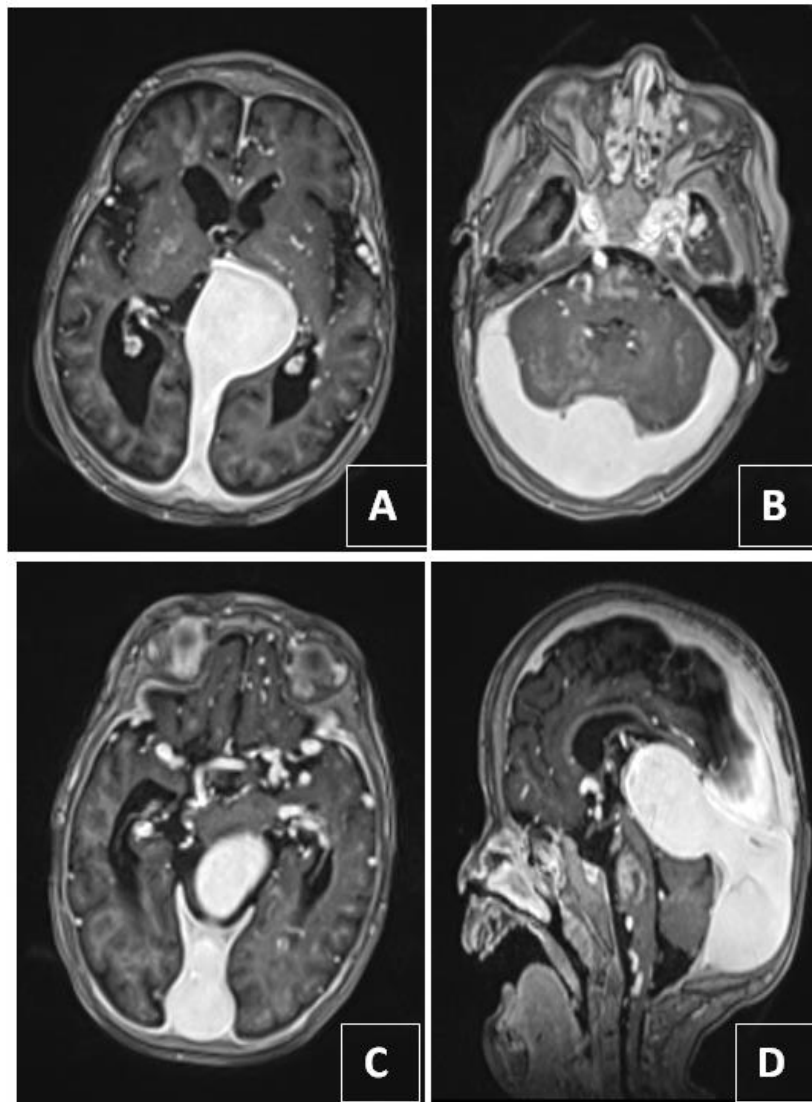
MRI after injection of gadolinium product in T1 axial (A, B, C) and sagittal (D) sections showing vascular-type enhancement of the aneurysmal dilatation of the ampulla of Galen extended to the right sinus, the torcular, the superior sagittal sinus, and the transverse sinuses bilaterally. It is associated with dilatation of several cortical drainage veins, internal cerebral veins, basilar veins of Rosenthal, internal temporal veins and cavernous sinus (yellow arrow)
